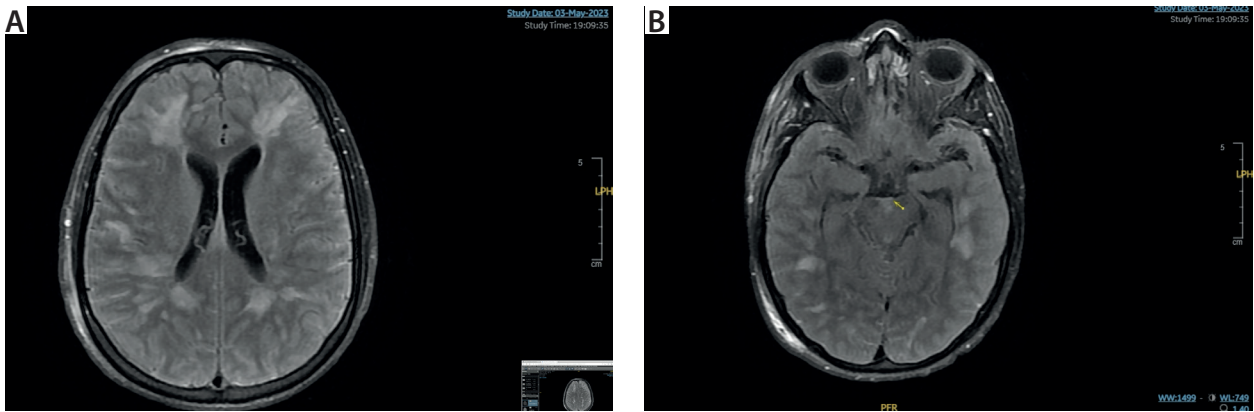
Initial magnetic resonance imaging: multiple confluent focal areas of restricted diffusion bilaterally and symmetrically, predominantly in the frontal and bilateral peritrial regions, and in the semioval centres, consistent with cytotoxic damage, suggesting acute ischaemic lesions in the context of probable associated vasculitis. Bilateral frontal punctate susceptibility artefacts, within the signal alteration, suggestive of small haemorrhagic foci
